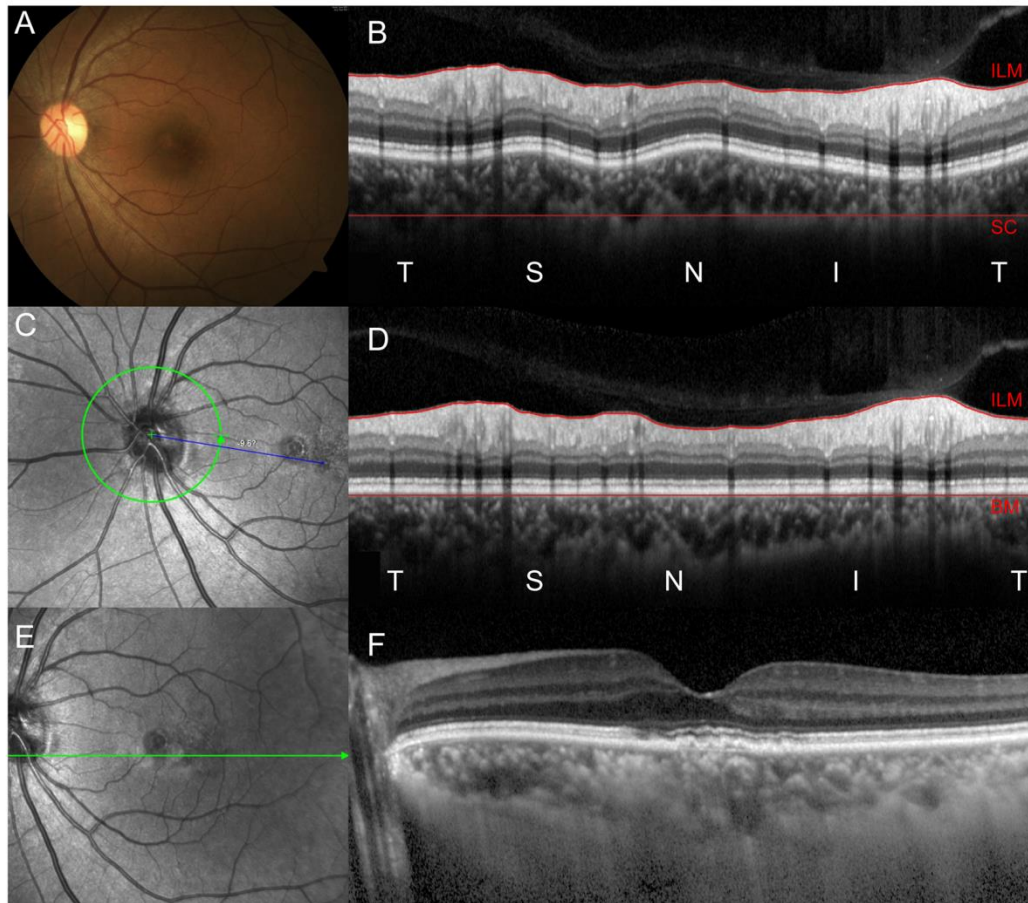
Measurement of peripapillary choroidal thickness (PCT) and subfoveal choroidal thickness (CT). (A) Fundus photography of 56 years old female with polypoidal choroidal vasculopathy (C) A 360° 3.4 mm diameter circle scan around the disc were performed to obtain
